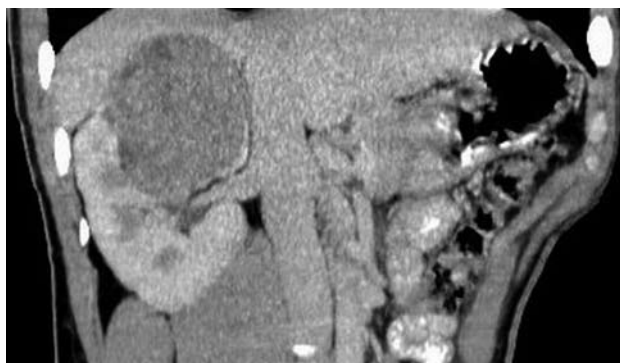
A 23-year-old male with right kidney malignant fibrous histiocytoma. Non-contrast computed tomography scan coronal view shows soft tissue mass of 47 HU in the upper pole of the right kidney extending toward the renal pelvis.
